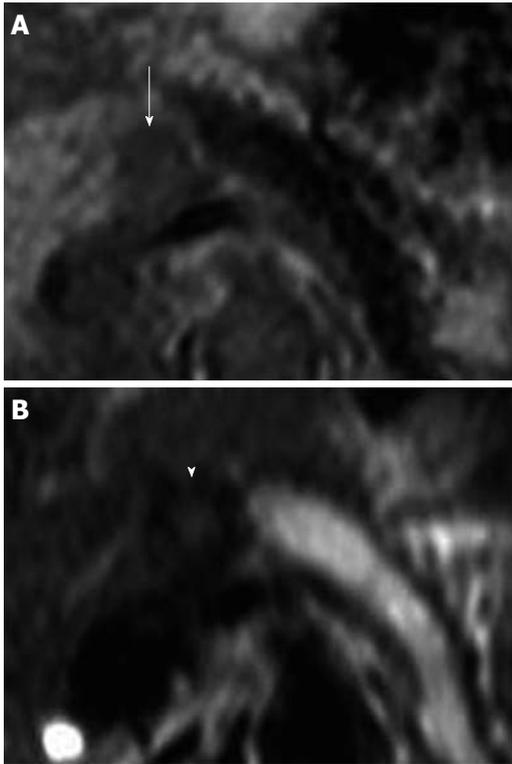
CT image of pancreatic GCT. A: CT showing poor enhancement of the tumor compared with that of the surrounding pancreatic parenchyma at early phase of dynamic CT (arrow); B: CT showing gradual enhancement of the tumor at delayed phase (arrowhead). CT: Computed tomography.
